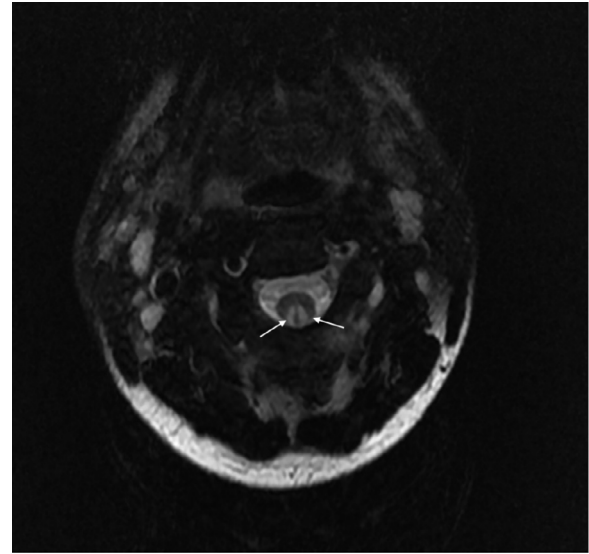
Mid sagittal plane view of T2-MRI sequence showing increased T2 signal intensity (arrows) in dorsal columns suggesting subacute combined degeneration.
